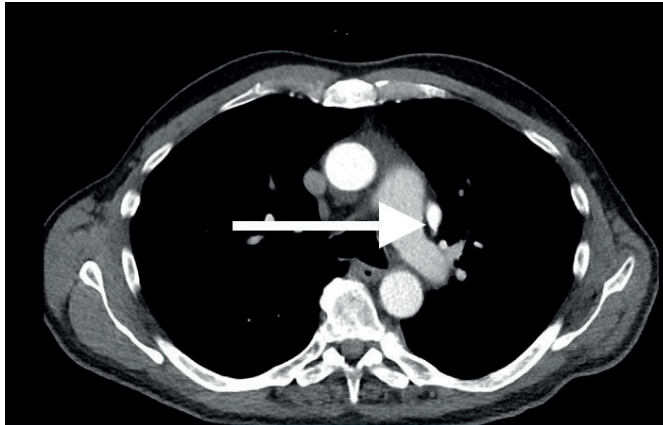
CT Chest reveals PLSVC
